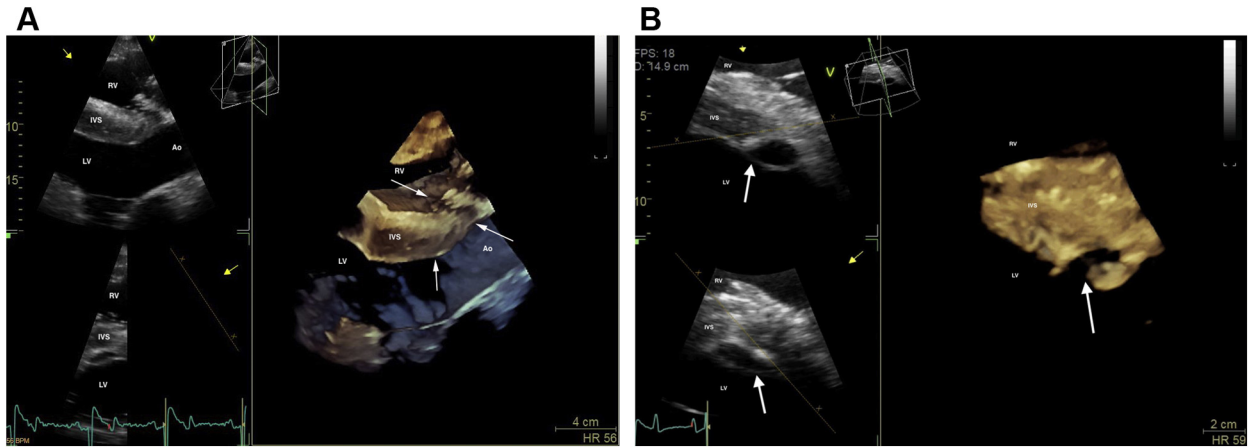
Three-dimensional (3D) echocardiograms of the ACF (A) and the subendocardial dissection (B) obtained from the right parasternal window immediately after ACF diagnosis. (A) Modified long-axis 3D image of the left ventricular outflow tract with slight cranial and dorsal obliquity. The right ventricular inlet is displayed in the near field. Arrows are pointing to the ACF. (B) Short-axis 3D image of the left ventricle, just below the mitral valve. The right ventricle is displayed in the near field. Arrows are pointing to the subendocardial dissection. Ao, Aorta; IVS, interventricular septum. LV, left ventricle; RV, right ventricle.
